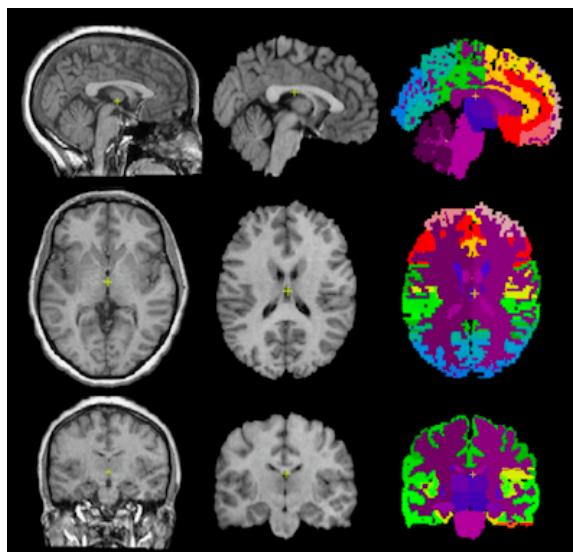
Representative maps of the white and gray brain matter in T1-weighted images. Segmentation of the brain
